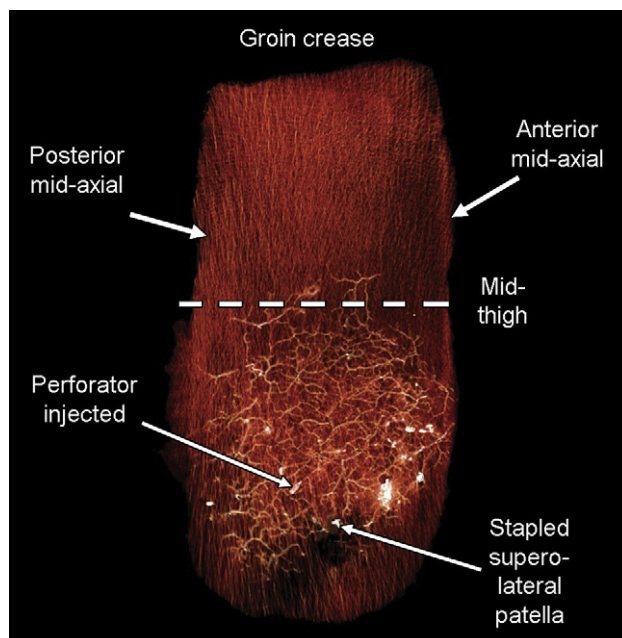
3D CT angiogram of injected lateral supragenicular perforator adipocutaneous flap, AP view (Margins: groin crease, inferior level of the patella, anterior mid-thigh and posterior mid-thigh).
